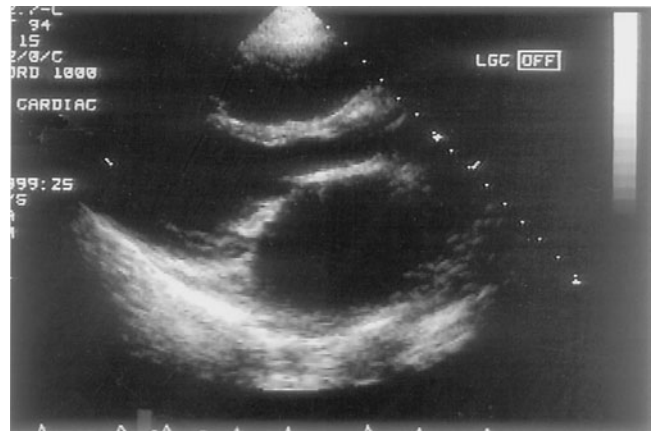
Echocardiogram (long axis) of a patient with severe mitral stenosis owing to rheumatic heart disease. A thickened, stenotic valve separates an enlarged left atrium (*right*) and the left ventricle (*left*) and outflow tract (*above*).
